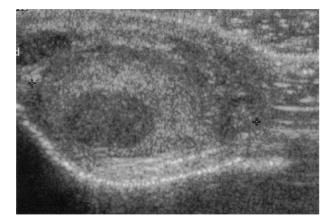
Longitudinal scrotal ultrasonography of a man with nonmosaic Klinefelter syndrome. An intratesticular tumor of less echogenicity than the surrounding testicular parenchyma is seen (score 5). The tumor was not palpable by clinical examination and proved to be a Sertoli cell tumor.
